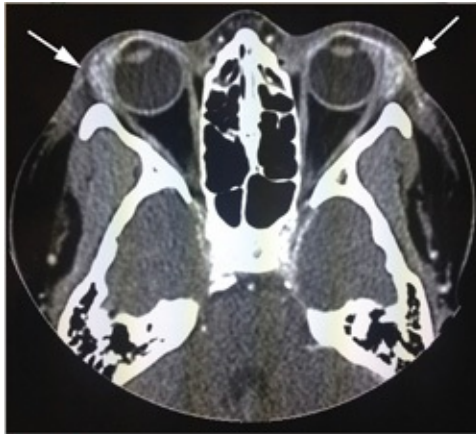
Bilateral dacryoadenitis on CT scan (arrows).
